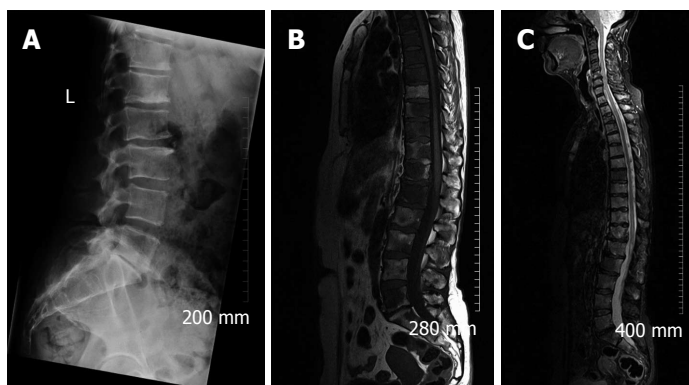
Magnetic resonance imaging is superior to plain radiography for detection of bone metastasis. A: Lateral lumbar spine radiograph demonstrates subtle sclerotic metastatic deposits at the inferior endplate of T12 and L1 from a primary breast malignancy; Sagittal T1 (B) and short tau inversion recovery (STIR) (C) images of the spine acquired one day later demonstrate diffuse bone metastasis (abnormal low T1 and high STIR signal in the bone marrow) which is not evident on the radiograph.
